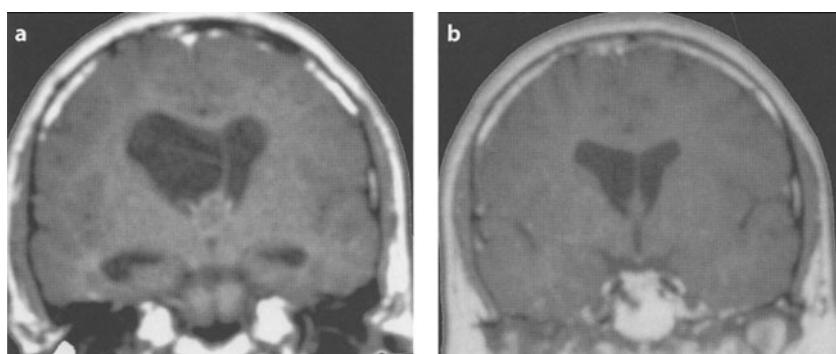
Ventriculomegaly decreased after endoscopic removal of colloid cysts. a Preoperative and b postoperative (at 2.5 years) MRI, coronal sections
